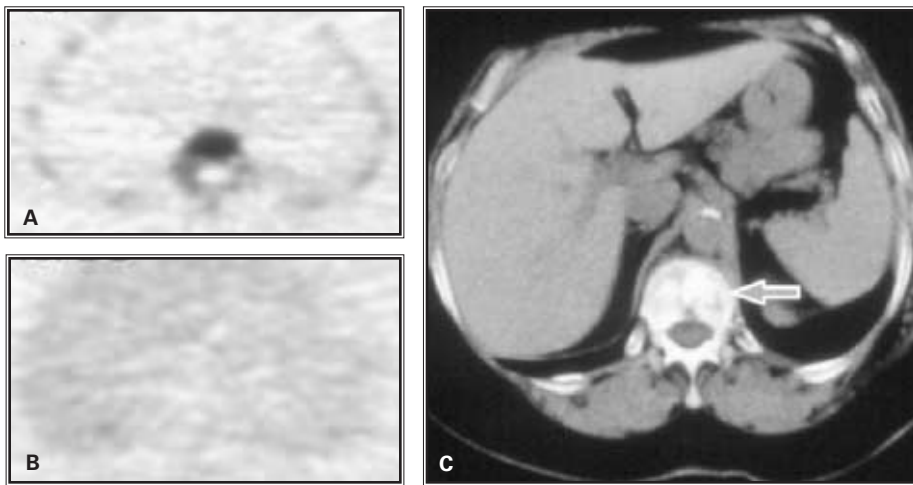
Transaxial F-18 fluoride (A), FDG (B), and CT (C) scans demonstrate focally increased bone turnover in sclerotic metastasis (arrow) but with no abnormal FDG activity.
